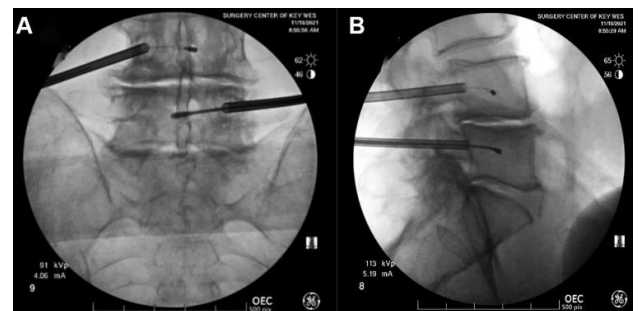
The X-ray View in AP and Lateral for Basivertebral Nerveablation (16).
